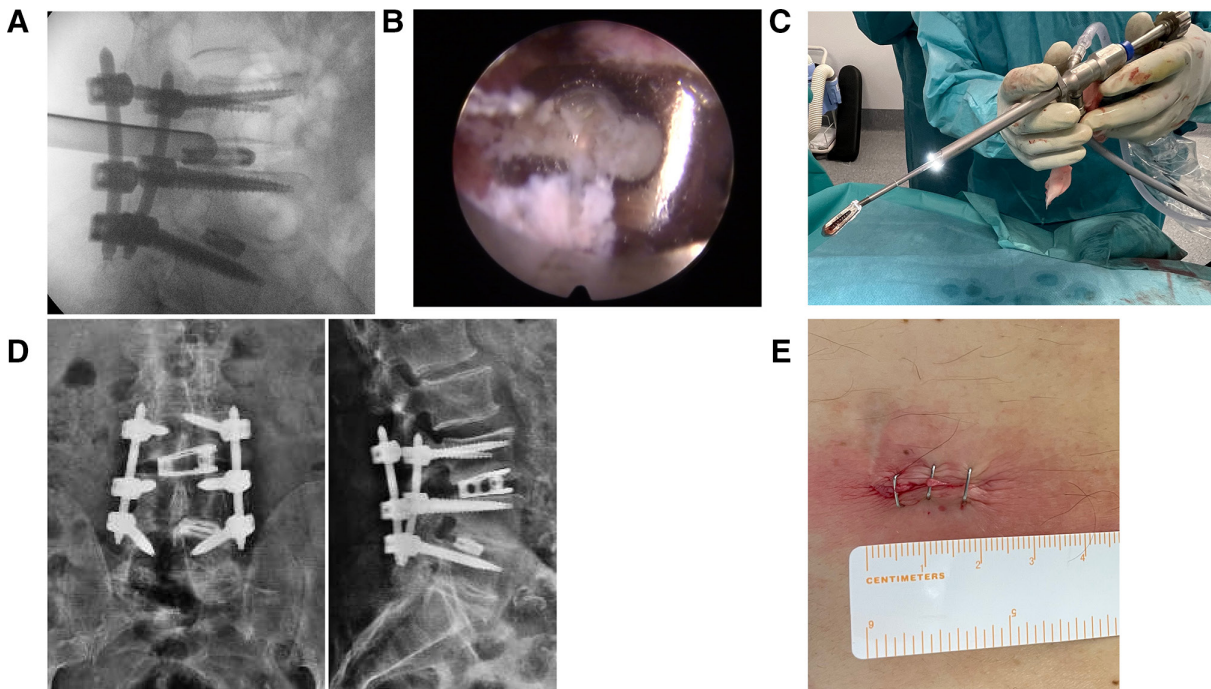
(A) Lateral intraoperative fluoroscopic image of the specialized fusion dilator sleeve positioned into the disc close to the migrated cage at L3-L4. The sleeve protects the right L3 exiting nerve root. (B) Endoscopic view of the migrated titanium interbody cage. (C) Photo of the removed interbody cage attached to the cage handle. The cage handle can be seen looking out the working channel of the endoscope. (D) Postoperative x-ray control images of the lumbar spine in anterior/posterior (left side) and lateral (right side) views. Notice the large footprint, expandable titanium cage that was placed as a substitute at L3-L4. (E) Skin incision of 2-cm length through which the migrated interbody cage was removed, and the substitute large footprint expandable cage was placed into L3-L4 with the trans-Kambin approach.
